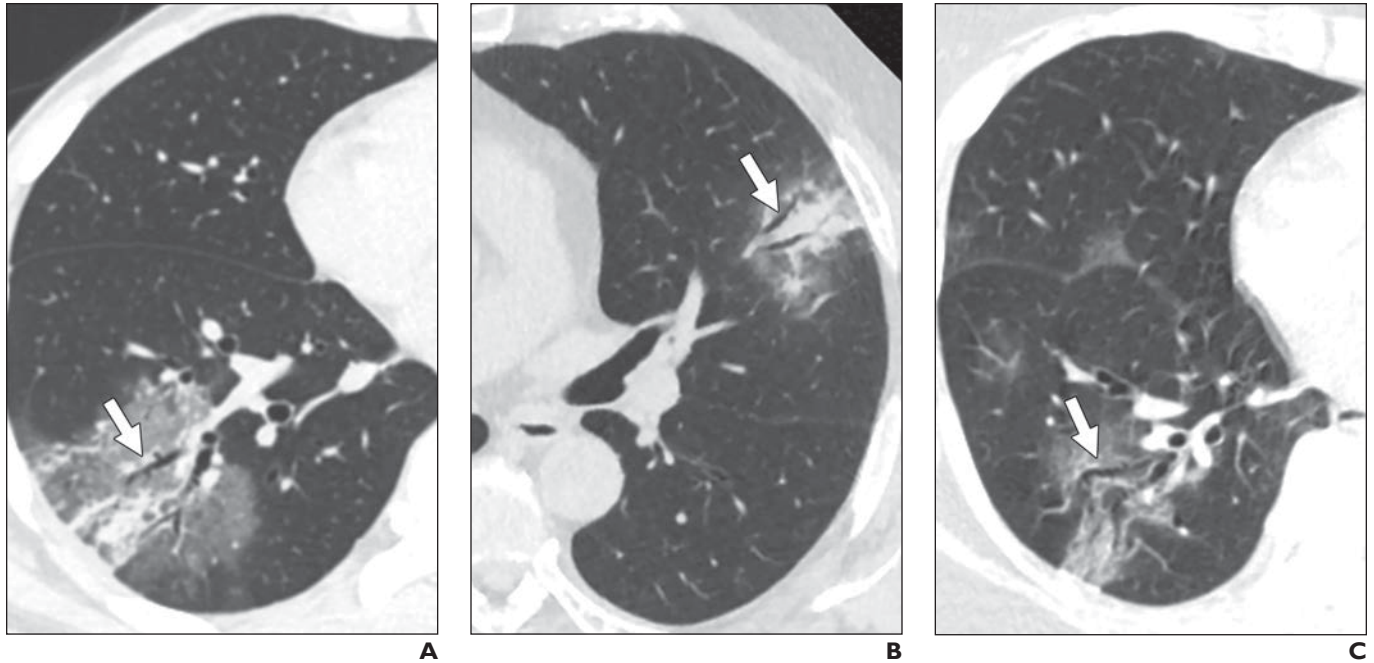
CT features indicating bronchial changes caused by coronavirus disease 2019 pneumonia.
